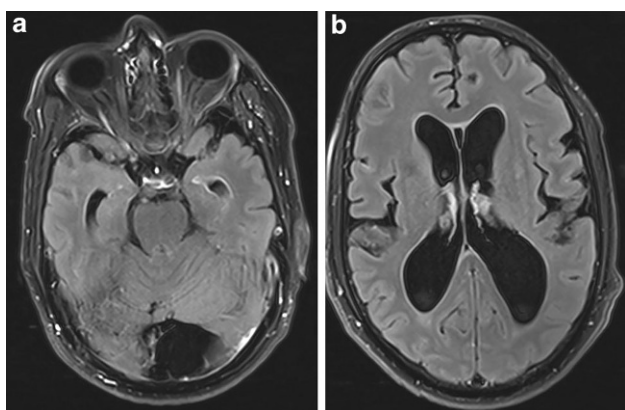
Axial T2 FLAIR post-contrast images depicting communicating hydrocephalus along with thin diffuse leptomeningeal enhancement and mild enhancement of the ependymal lining of the bilateral temporal horns of the lateral ventricles
